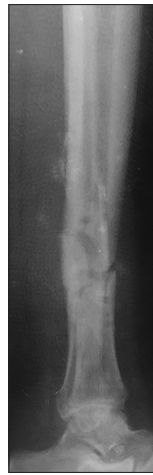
Immediate post-operative lateral radiograph of the index case
